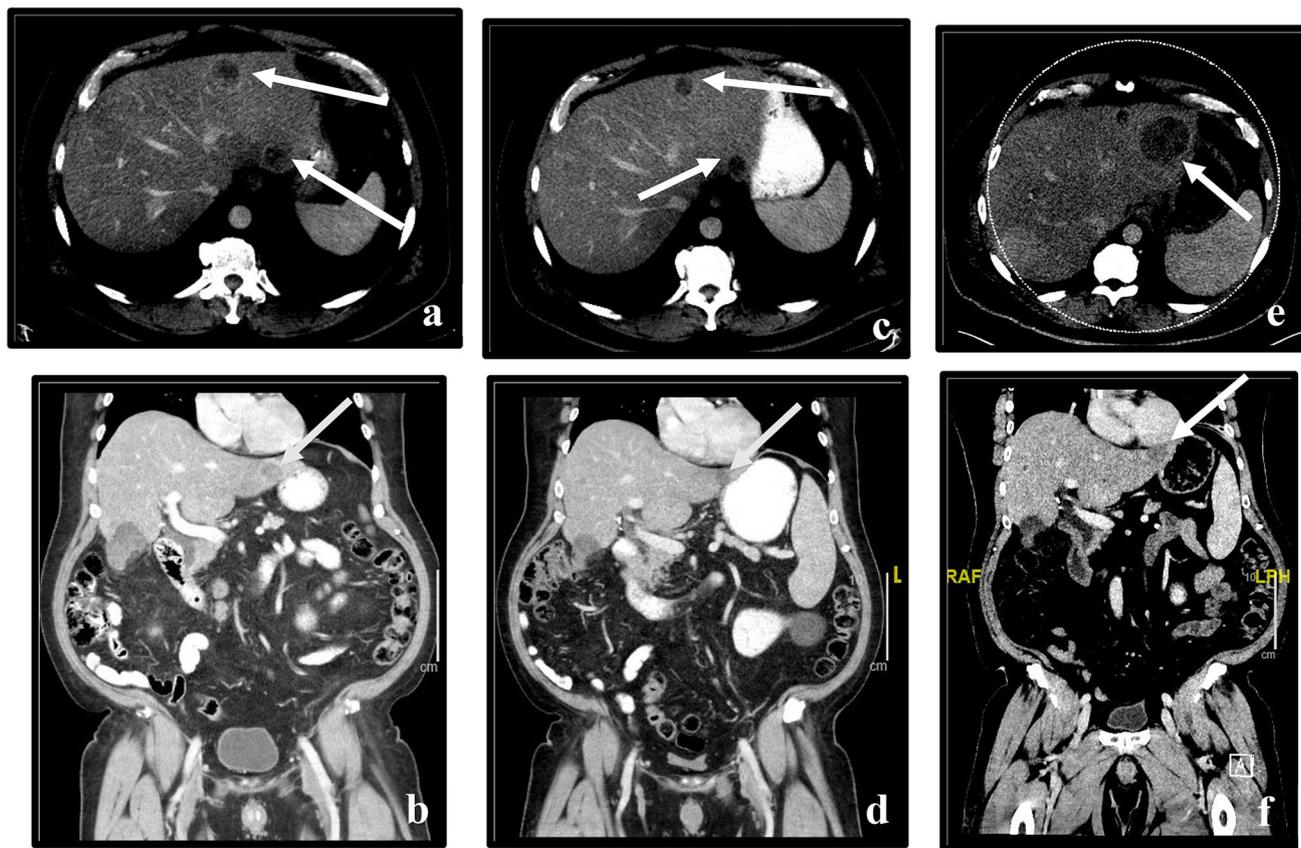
A 64-year-old-male with metastatic pancreatic adenocarcinoma who developed liver metastases while being treated with first-line FOLFIRINOX. Contrast-enhanced axial and coronal CT images after 2 years of FOLFIRINOX treatment show development of several hypodense metastatic lesions in the right and left hepatic lobes, compatible with metastatic lesions (arrows in a, b). The
